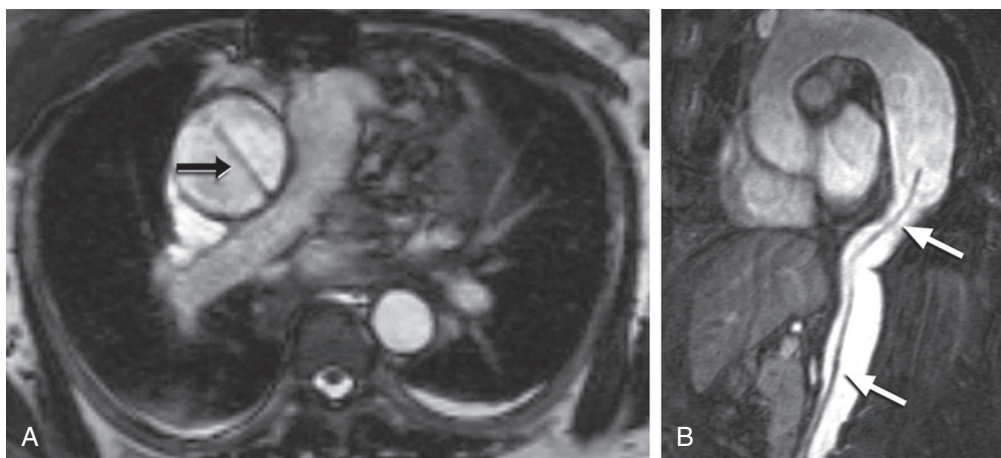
FIGURE e57-10 MRI in a patient with aortic dissection. A, Type A aortic dissection with an intimal flap (arrow). B, Type B aortic dissection with an intimal flap (arrows) and aneurysmal enlargement of the proximal descending aorta.
